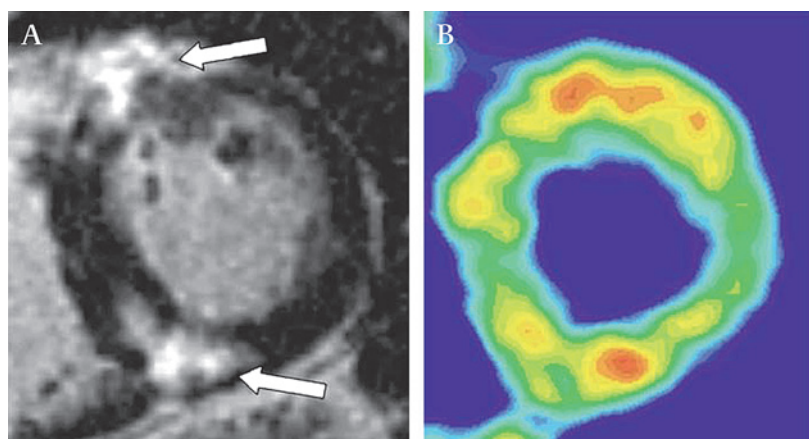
(A) Mid ventricular short axis view of a gadolinium delayed enhanced cardiac magnetic resonance image of a patient with hypertrophic cardiomyopathy. Note patchy hyperenhancement located at hypertrophied interventricular septum at junctions of septum and right ventricular free walls (arrows). (B) Anatomic tissue fraction image of same patient derived by positron emission tomography. Reproduced with permission from Knaapen *et al.*^{w20}
